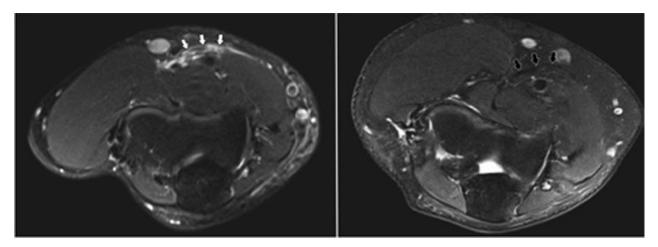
Lacertus fibrosus tear (white arrows) demonstrated on an axial T2-weighted magnetic resonance imaging sequence of a patient with a partial distal biceps rupture, with comparison with an intact lacertus fibrosus (black arrows) demonstrated in a different patient with a partial distal biceps rupture.
